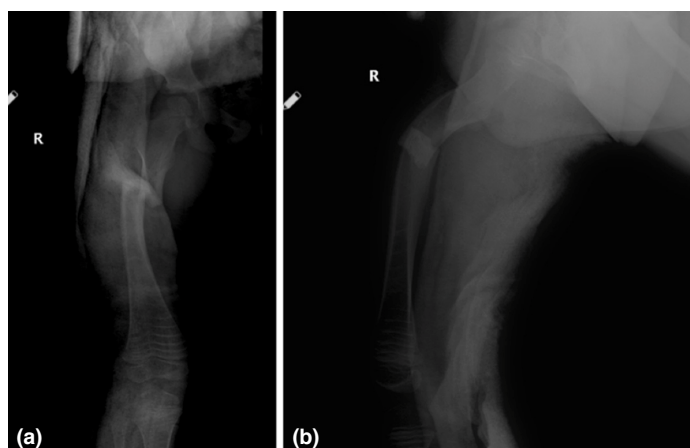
X-ray images of the patient with pelvipedal brace. (a) Right femur ap view. (b) Right femur lateral view.
